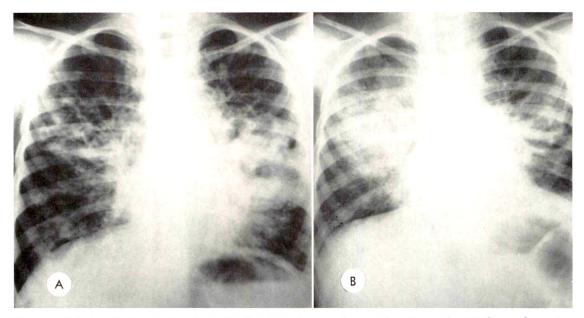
(A) Chest roentgenogram of a cystic fibrosis patient at  $4\frac{1}{2}$  years shows necrosis and abscess formation to have destroyed so much of the lung parenchyma as to preclude normal pulmonary function. (B) In spite of vigorous antibiotic therapy for  $1\frac{1}{2}$  years, the pulmonary infections spread. Nine days after B, the patient died.
